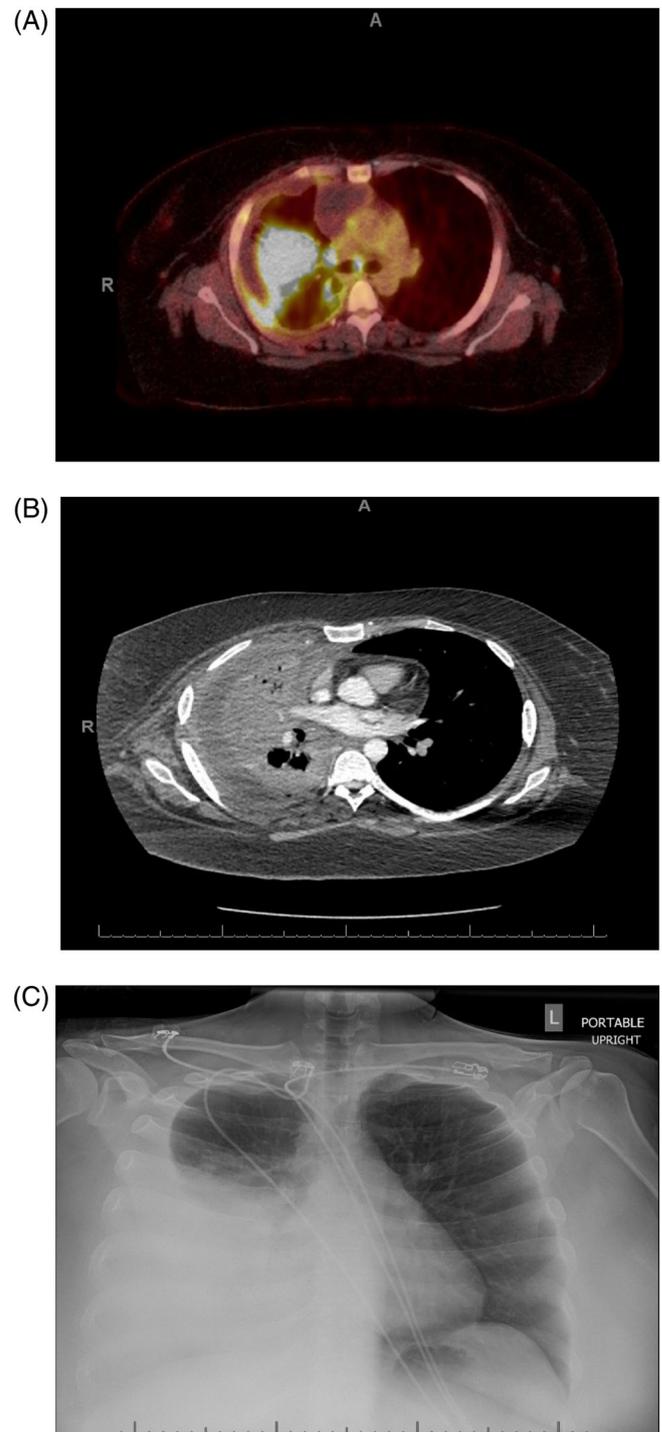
(A) PET-CT scan shows a right lung mass involving pleura. (B) CT scan of the chest revealed a mass in right middle and upper lung. (C) Chest X-ray with right sided pleural effusion
